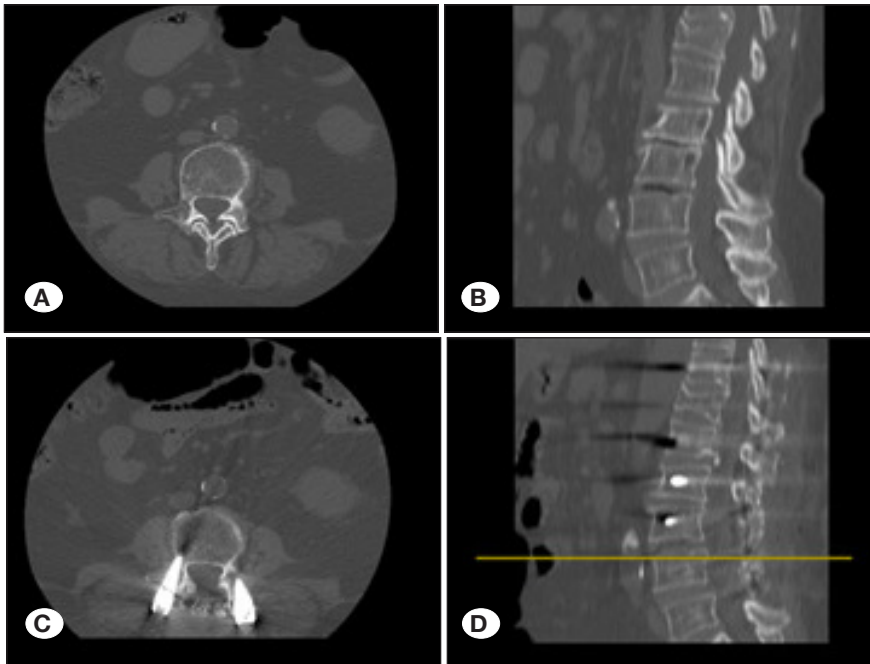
Preoperative/postoperative CT images of the patient who underwent L2-L3-L4 bone graft insertion. A) Preoperative L4 vertebra axial view, B) preoperative sagittal view, C) postoperative L4 vertebra axial view, D) postoperative sagittal view.
